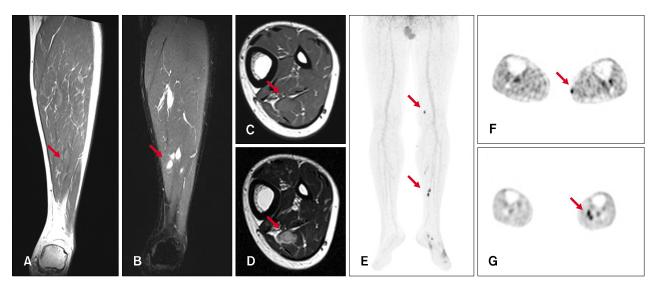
Magnetic resonance imaging of pseudomyogenic hemangioendothelioma patient. (A \sim D) Magnetic resonance imaging of axial T1 image (A), axial T2 image (B), coronal T1 image (C), and coronal T2 fat-saturated image (D) shows several well defined nodules in the skin and gastrocnemius muscle with T1 intermediate, homogeneous enhance and T2 high signal intensity (arrows). (E \sim G) Positron emission tomography-computed tomography reveals multiple hypermetabolic lesions on skin and muscle (arrows).
